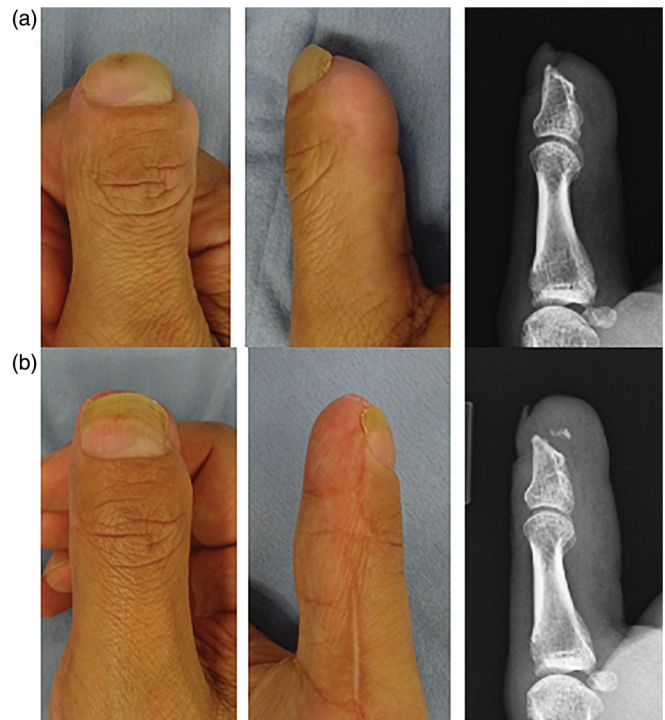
38-year-old man, left index finger. (a) Preoperatively, a-1: frontal view, a-2: lateral views, a-3 lateral view in X-ray, (b) Nine months after reconstruction with a reverse digital arterial finger flap and bone grafting from the second toe. b-1: frontal view, b-2 lateral view, b-3 lateral view in X-ray.
